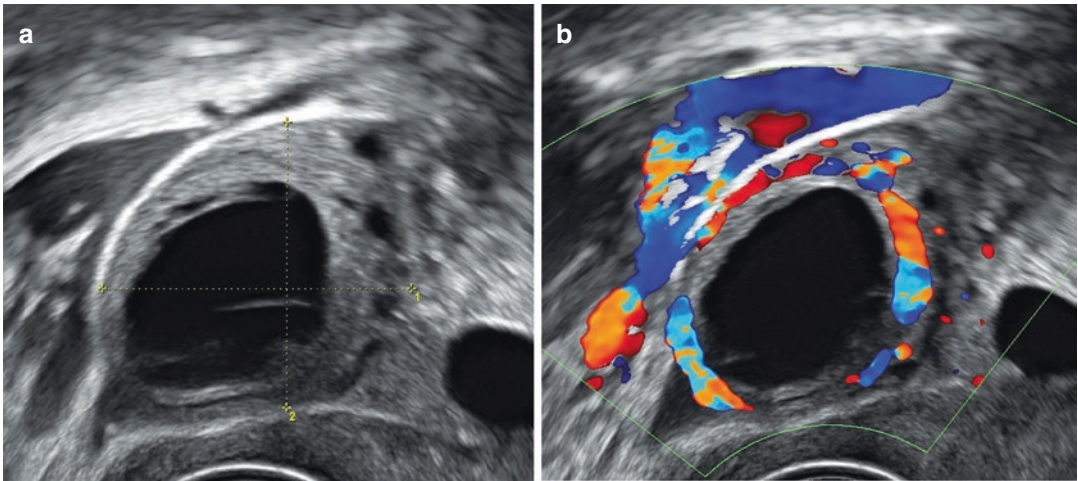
Assessment of corpus luteum. (a) A grayscale image of a cystic corpus luteum which is surrounded by normal ovarian tissue. (b) Color Doppler showed typical “ring of fire” distribution of blood vessels
